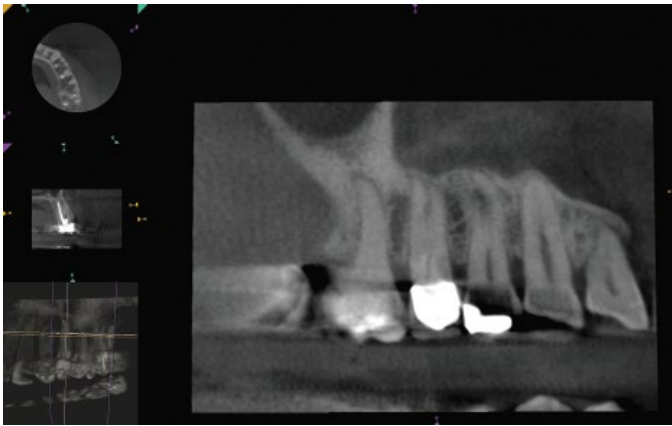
(C) CBCT sagittal plane image shows two untreated buccal canals. Reproduced with permission of Dr J. Chikvashvili.
